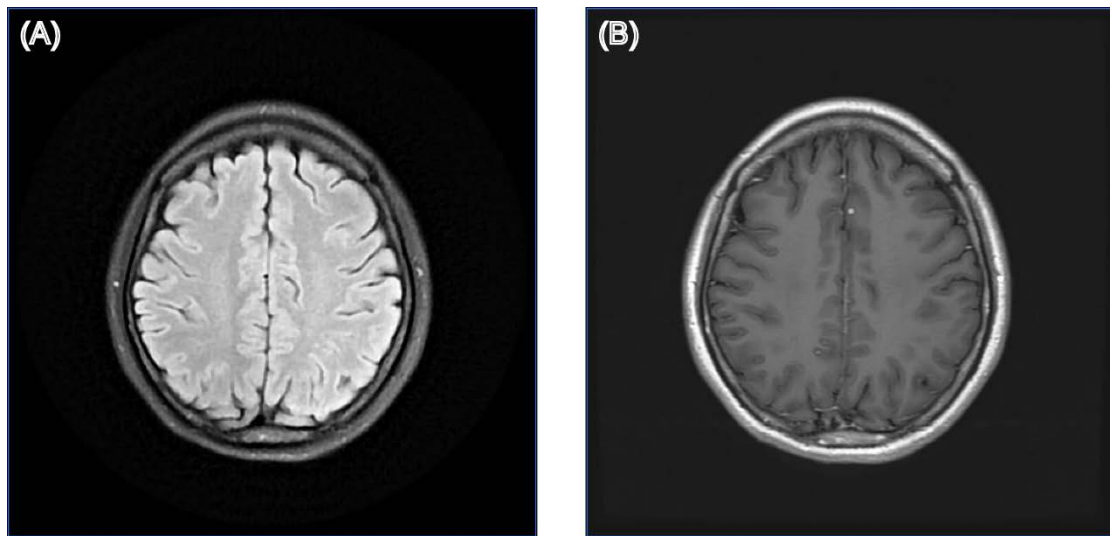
Structural brain MRI images of patient 05. (A) T2-weighted fluid-attenuated inversion recovery (T2-FLAIR) image; (B) Gadolinium-enhanced T1-weighted (Gd-T1w) image.
